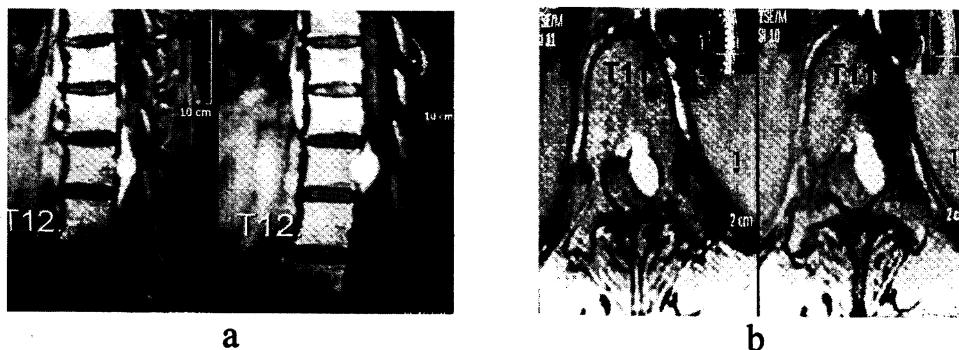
Sagittal (a) and axial (b) MRI T1WI with gadolinium of lower thoracic level, the lesion at left side of T11, $1.0 \times 1.3 \times 2.1$ cm. in size also extradural compression and displaced spinal cord to the right.
